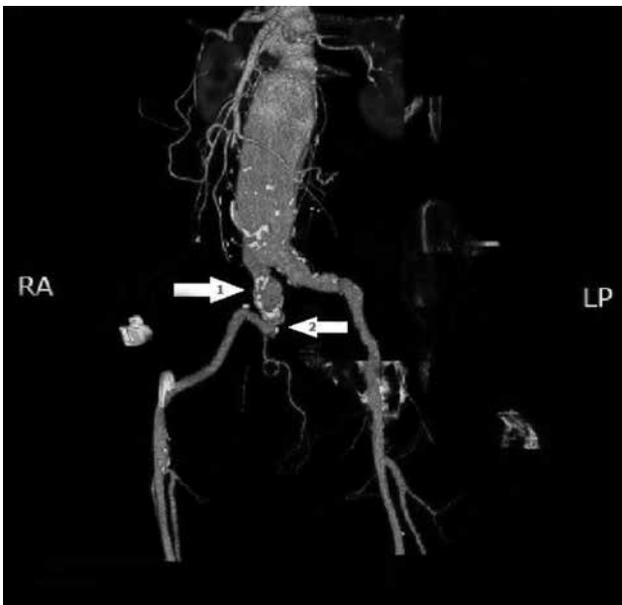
Preoperative three-dimensional computed tomography angiography reconstruction. Arrow 1: A right common iliac aneurysm; Arrow 2: A severely tortuous right iliac artery with "S" appearance.
